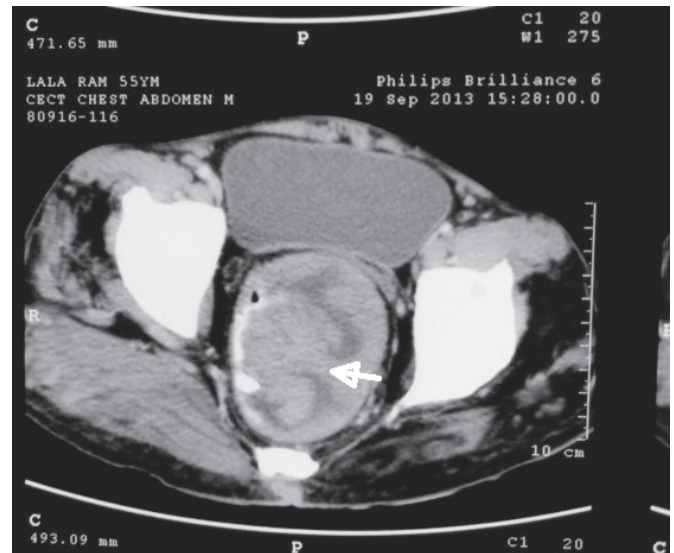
Computer tomogram (CT) of abdomen shows a bulky soft tissue mass arising from anal canal and rectal wall extending from anal verge to recto-sigmoid junction. polypoidal stalk is identified (arrow).
